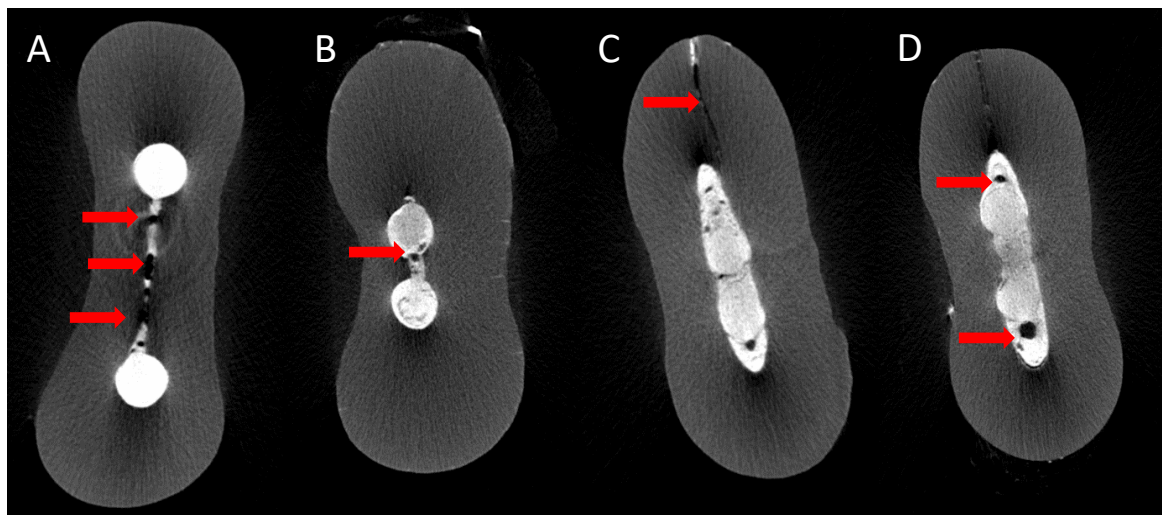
Cross-sectional μ CT images show the gaps and voids areas found in obturated natural molars (red arrow). A: gaps at the isthmus area, B: gaps at the junction between the warm GP and the matched single-cone, C: gaps at the lateral canal and D: gaps at the canal irregularity
